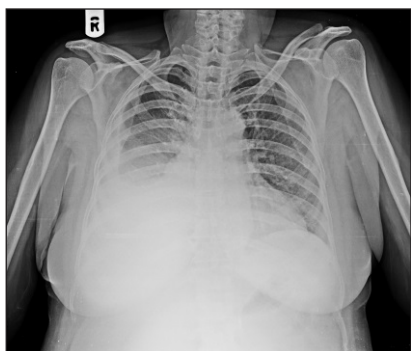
Pre-operative chest X-ray with gross effusion
